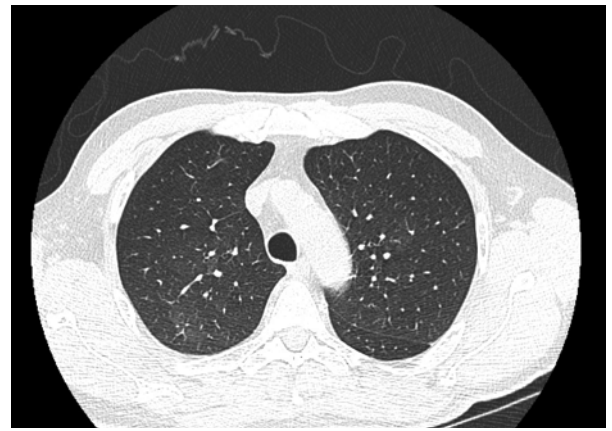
Thorax high-resolution CT scan 55 hours after the initial examination
